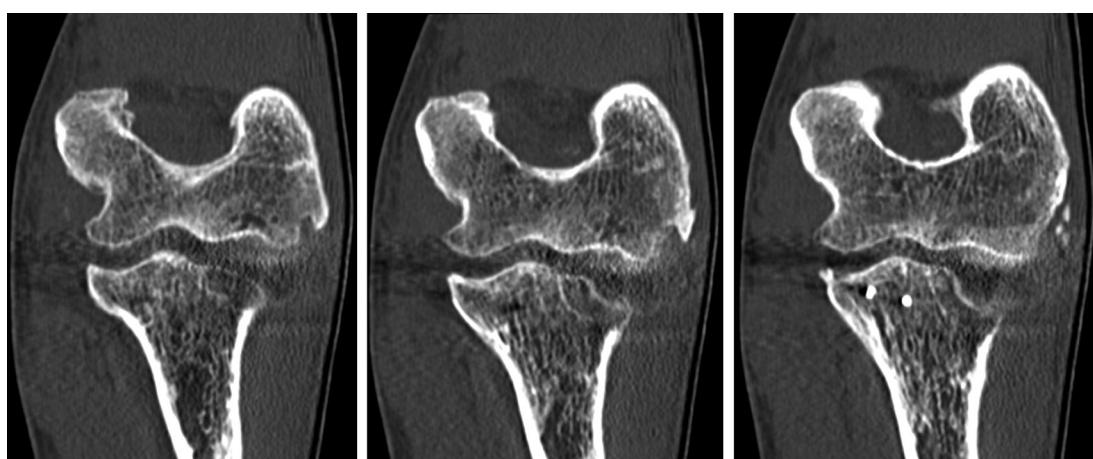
Preoperative CT scan prior to radiocapitellar arthroplasty. Congruent ulnohumeral joint space without signs of significant osteoarthritis.
